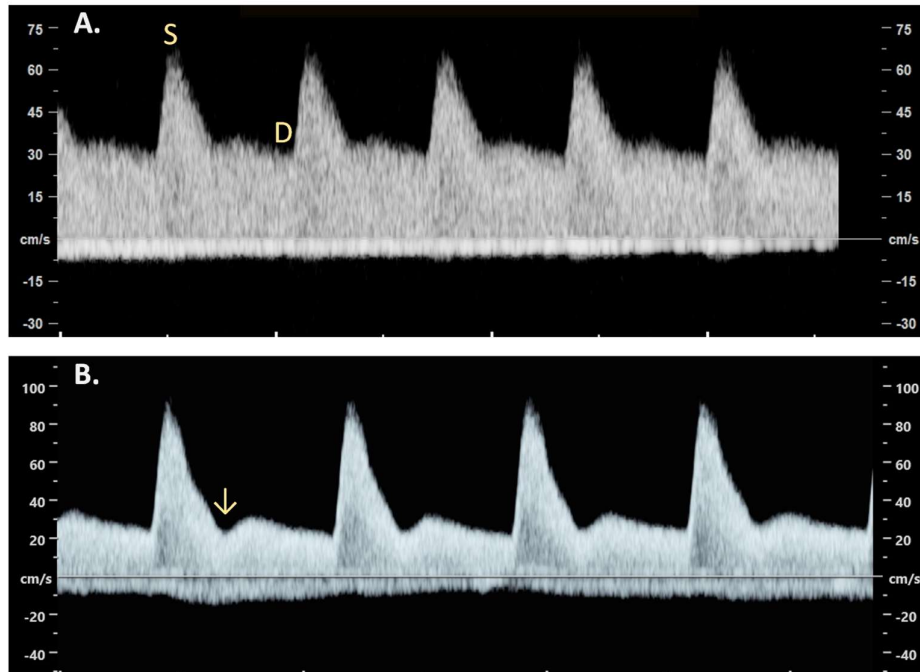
A. Normal Doppler waveform of the uterine artery imaged with contemporary ultrasound equipment. S is the peak systolic velocity and D is the least diastolic velocity. B. Uterine artery Doppler waveform depicting high resistance and a pre-diastolic notch (arrow). Images produced by D Paoletti.
